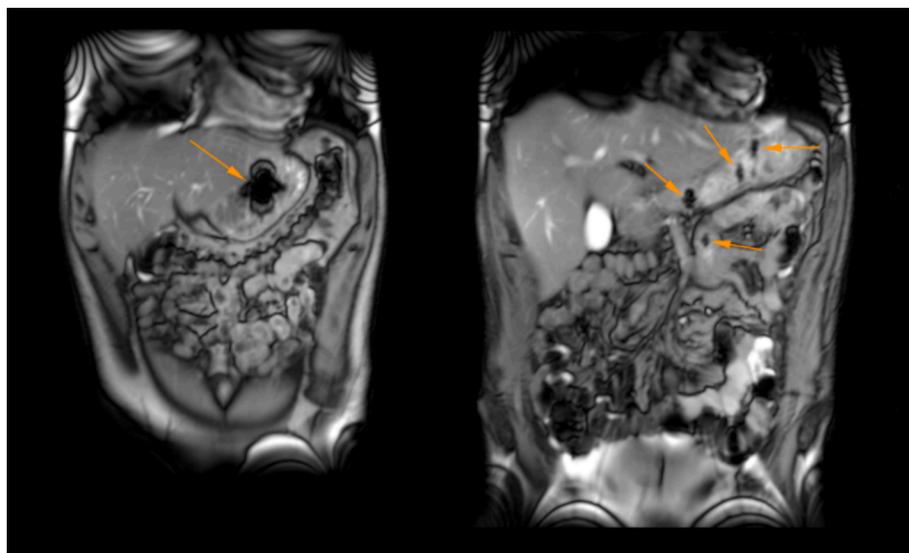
Exemplary coronal T2 weighted MRI images taken 4 h after food intake. Objects are indicated by arrows. In the left image an intact tablet is located in the stomach (subject 9). In the right image, dispersed fragments of a tablet are located in the stomach and in the small intestine (subject 1).
